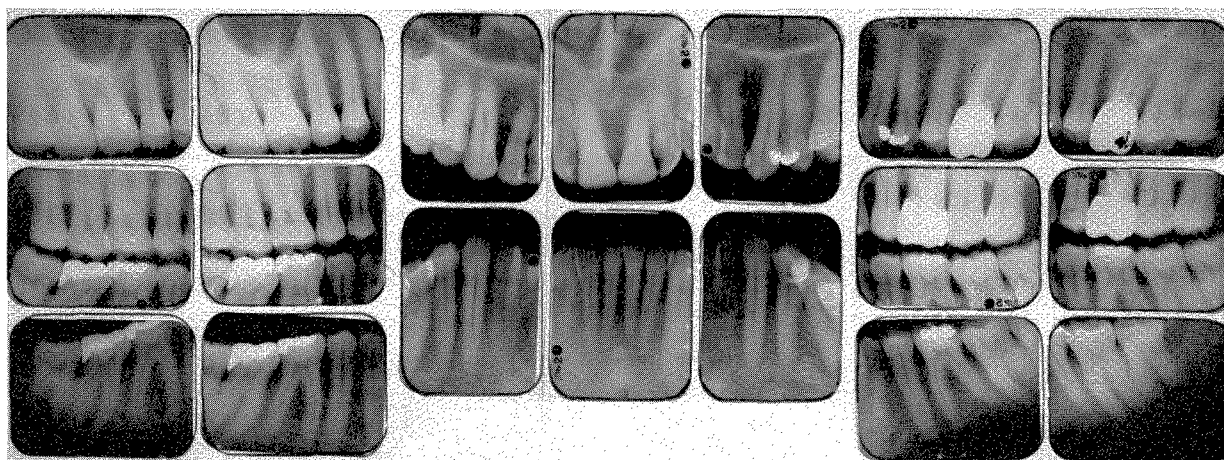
Roentgenograms taken in August, 1961, of the patient shown in Figs. 785 and 786. The teeth and osseous structures are in excellent condition.
